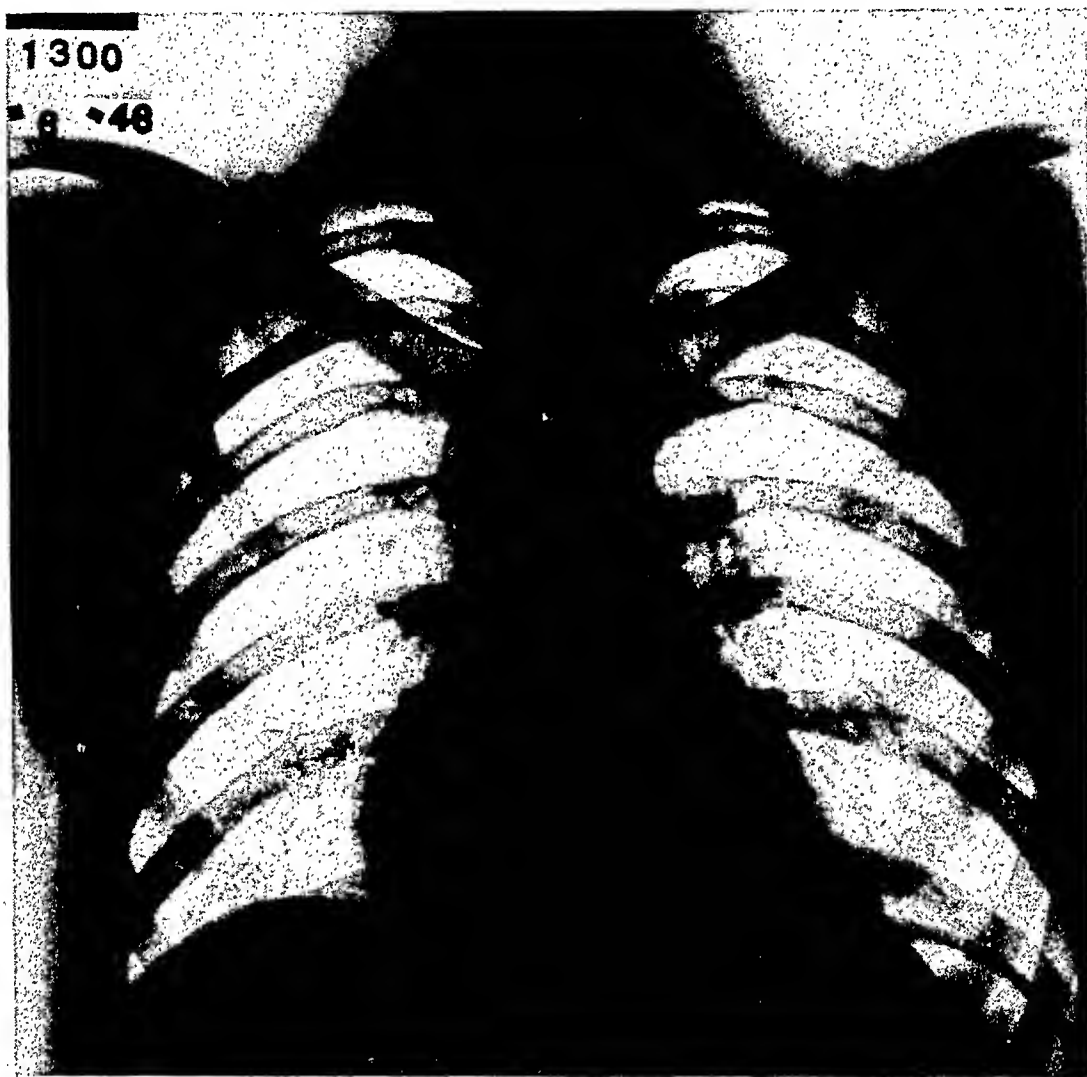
On day of rupture, x-ray negative. Size and contour of heart unchanged from previous films.
